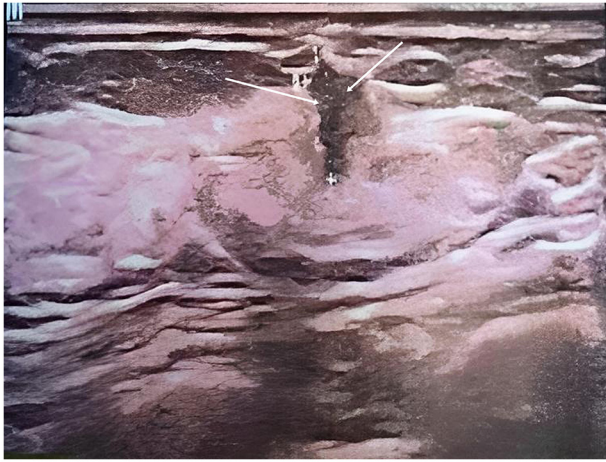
Ultrasound image of the tumor. A 15x20 mm irregular hypoechoic solid mass is visible (arrows), two transverse fingers from the nipple and 7.6 mm below the surface. This was assessed as Breast Imaging Reporting and Data System 4b at 1 o'clock in the left breast.
